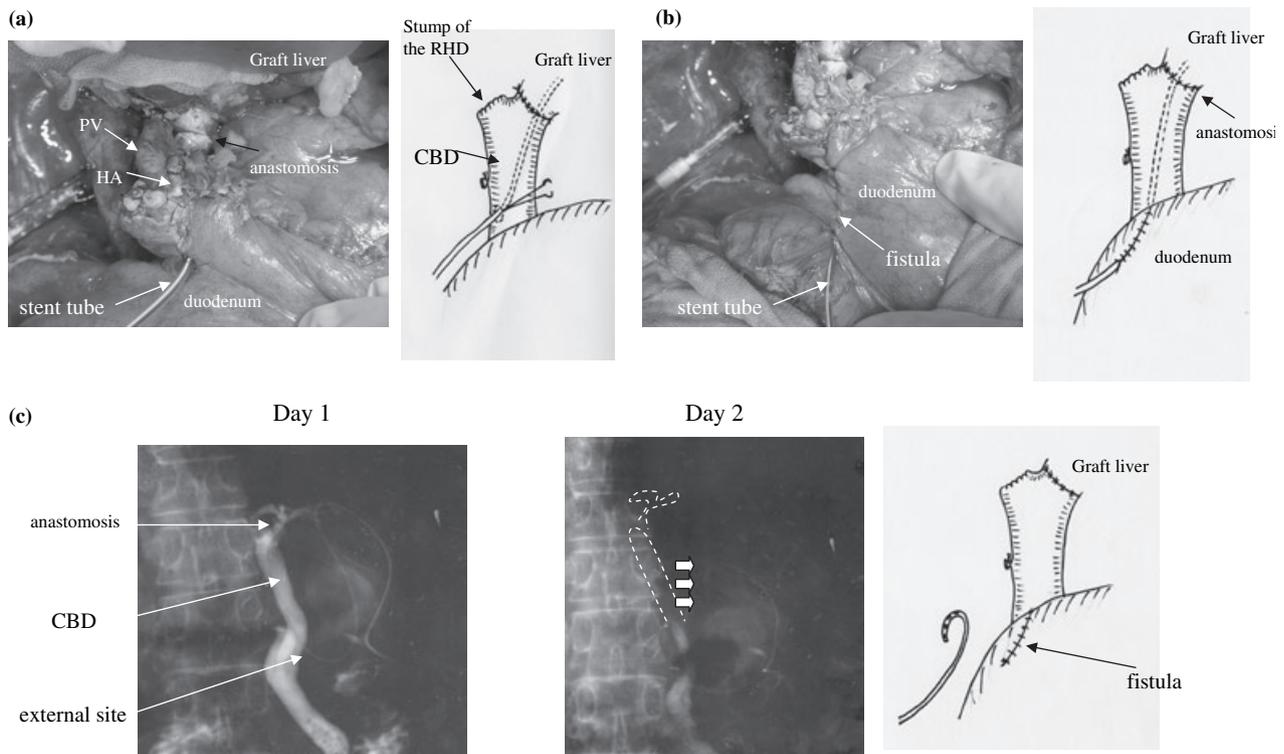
Method of biliary splinting and its two-step removal. (a) Two millimetres of tube is externalized from the lower common bile duct (CBD) just above the duodenum and stabilized with purse-string suture. PV: portal vein, HA: hepatic artery. (b) Additional Witzel-type canalization is made using the serosa of the duodenum. (c) On day 1, a cholangiogram is taken to ensure the lack of biliary complications after which the tube stent is partially withdrawn under X-ray and on day 2, the tube is withdrawn completely from the canal. Arrow indicates a tip of the tube stent outside of the CBD.
